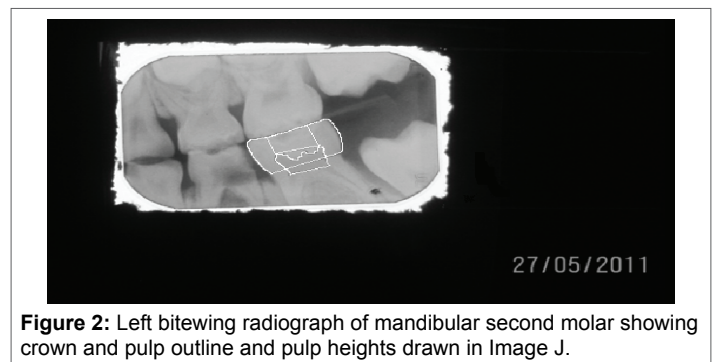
Left bitewing radiograph of mandibular second molar showing crown and pulp outline and pulp heights drawn in Image J.
